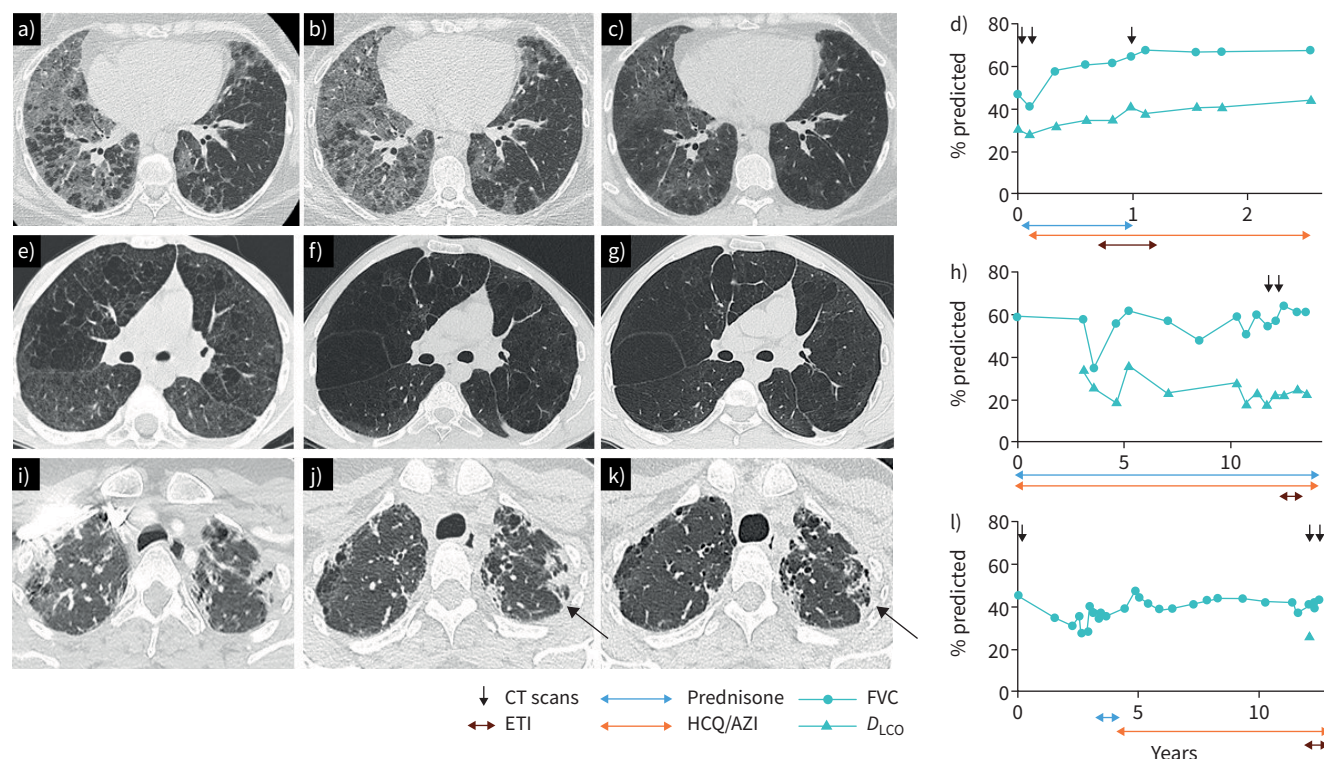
Evolution of CT scan and PFT before and after elexacaftor/tezacaftor/ivacaftor (ETI). Case 1, a) CT scan at diagnosis; b) after prednisone; c) after 3 months of ETI; d) evolution of PFT beginning from diagnosis. Case 2, e) CT scan in 2007 at the age of 8; f) before ETI; g) after 3 months of ETI; h) evolution of PFT beginning from 2010 at the age of 11. CT scan showed improvement of condensation (arrow) after ETI. Case 3, i) CT scan at diagnosis; j) before ETI; k) after 6 months of ETI; l) evolution of PFT beginning from diagnosis. CT: computed tomography; PFT: pulmonary function test; FVC: forced vital capacity, HCQ: hydroxychloroquine; AZI: azithromycin D_{LCO} : diffusing capacity of the lungs for carbon monoxide.
